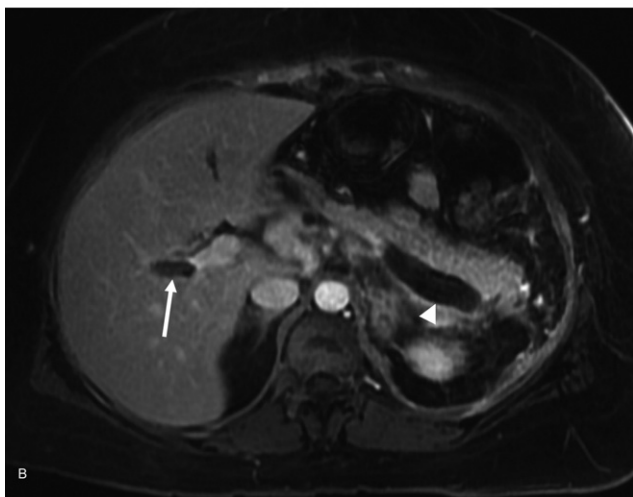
A 44-year-old woman with history of lymphoma and splenectomy presented with abdominal pain. (A) Precontrast CT study demonstrates hyperdensity within the right portal vein suggestive of acute thrombosis (arrow). (B) Axial post-contrast T1-weighted and fat-suppressed equilibrium phase MR image confirms the filling defect within the portal vein (arrow) as well as the splenic vein (arrowhead).
